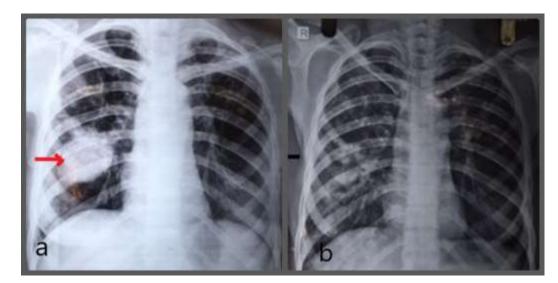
(a) X-ray chest showing a perihilar opacity extending towards right lower lobe (red arrow), (b) X-ray chest at 6 months follow up showing complete resolution of opacity (pseudoaneurysm)
